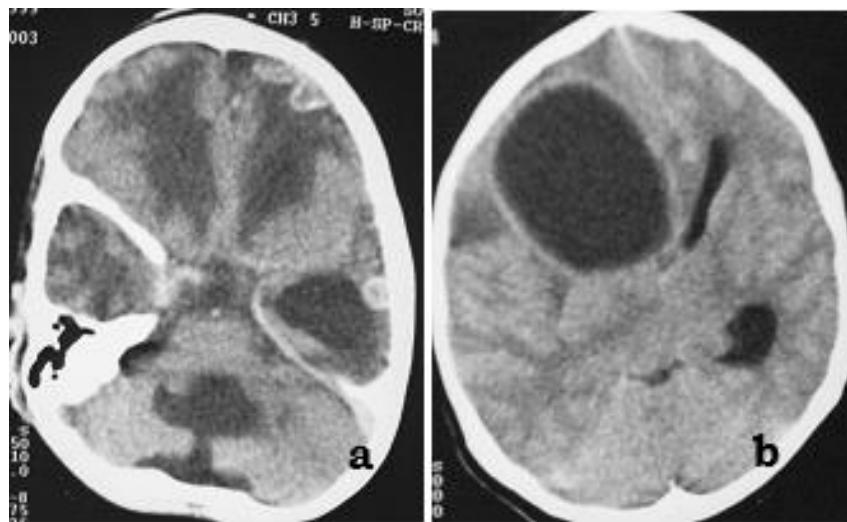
CT images of the brain showing a. Communicating hydrocephalus with dilated lateral, 3rd, 4th ventricles and basal cistern. b. Intracerebral abscess with ring enhancement due to bacterial meningitis.
